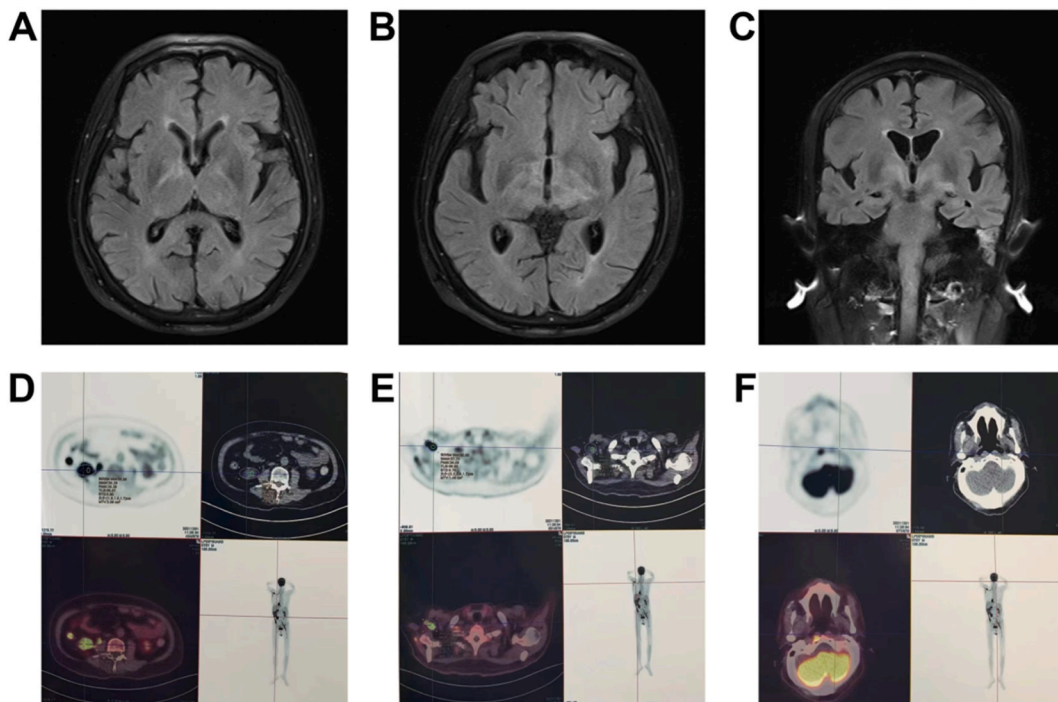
Changes of head MRI (A–C) and systemic ¹⁸F-FDG-PET (D–F) in this patient.
